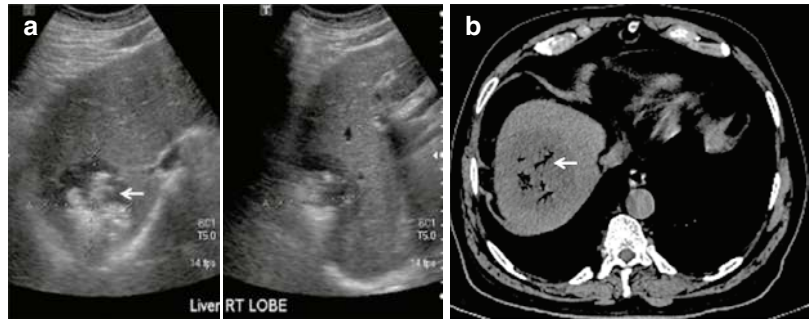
Pyogenic liver abscess. Ultrasound (a) and noncontrast CT (b) images show air within a large abscess in the right lobe of the liver, confirming the pyogenic origin of the abscess (arrows)
